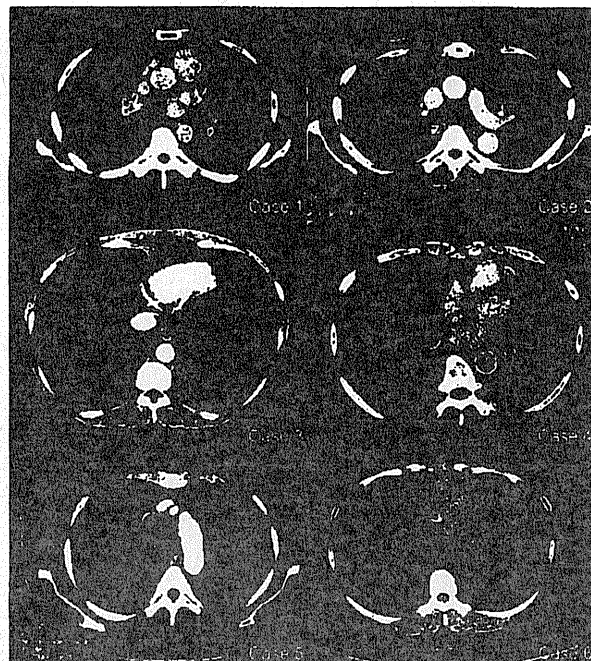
Chest computed tomography images show the variety of mediastinal tumors in cases 1–6.
